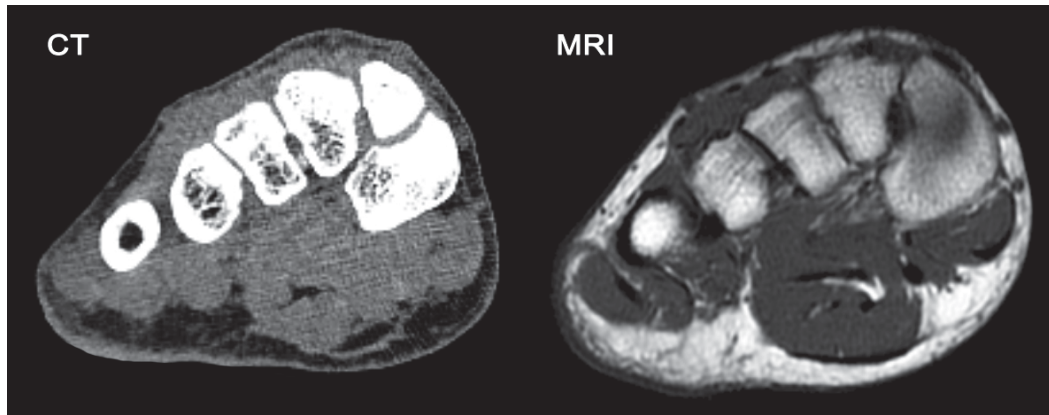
Left: Computer tomography image of midfoot. Right: Magnetic resonance image of midfoot.
